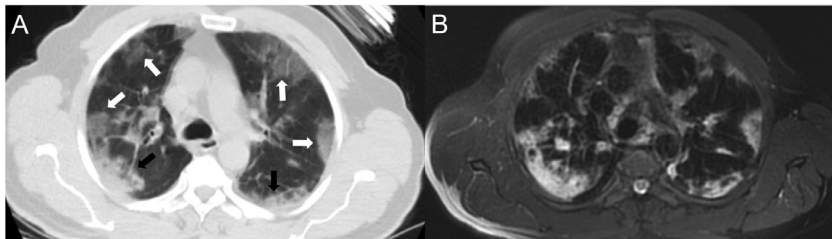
Images of an 81-year-old woman with peripheral-weighted diffuse involvement. In areas where there are ground-glass appearances (white arrows) on both CT (a) and MRI (b), vascular structures can be selected, while in the consolidated areas, vascular structures cannot be distinguished (black arrows).
